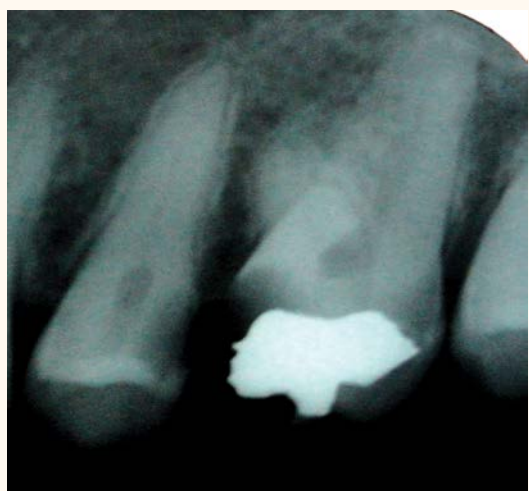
The initial radiograph showing the two-rooted maxillary first molar.
